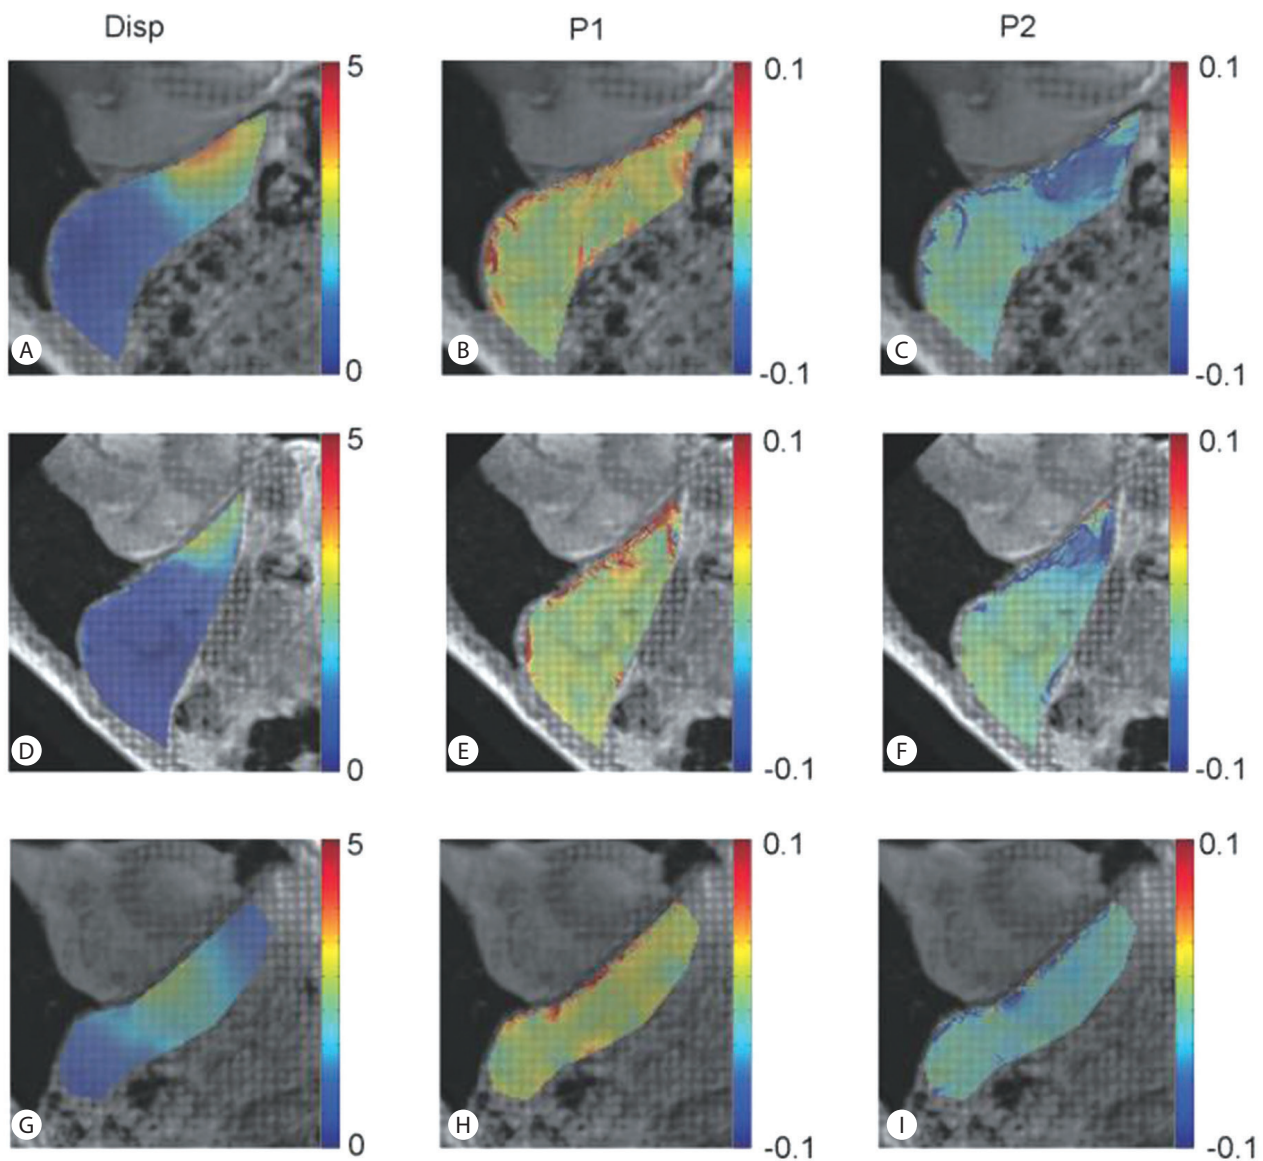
Representative grid-tagged MRI images with the superimposed color-coded corresponding displacement, P1 strain, and P2 strain maps of no fibrosis (A–C), moderate fibrosis (D–F), and significant fibrosis (G–I) patients relative to APRI scores, respectively. APRI, AST to platelet ratio index.
